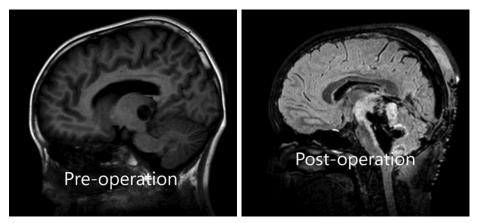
MRI finding in pre- and post-pineal tumour removal
